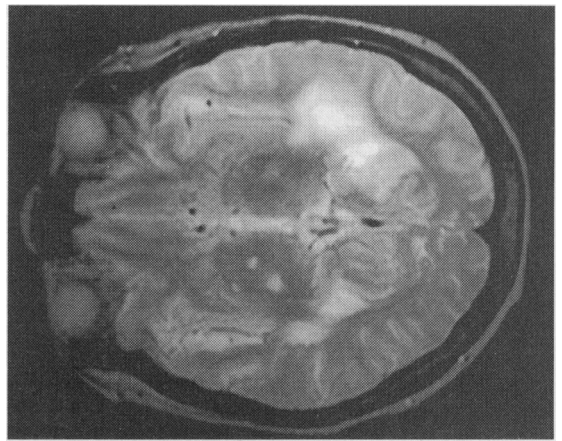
Magnetic resonance imaging scan showing multiple areas of increased signal in white matter in T2 weighted image
